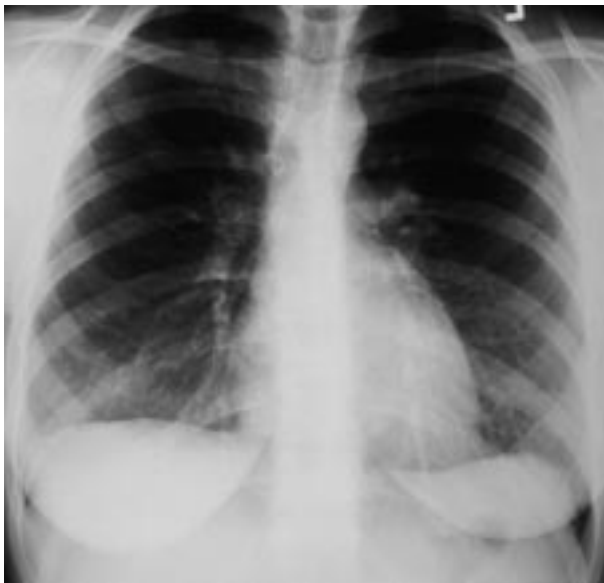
Chest radiograph frontal view, after remission, showing gradual improvement compared with radiograph at admission.
